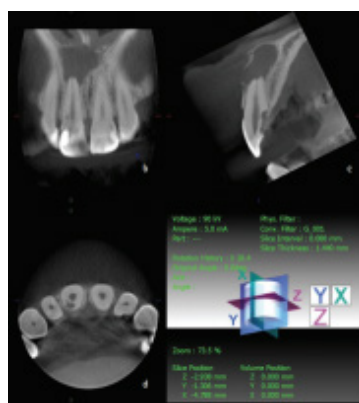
CBCT images from corona (b) sagittal (c) and axial (d) (Dawood et al., 2009).
